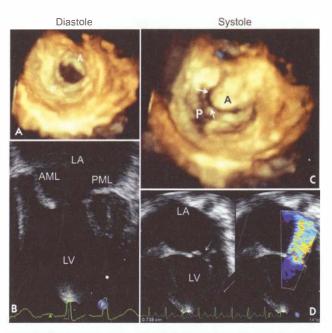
Rheumatic mitral valve disease with mitral stenosis and regurgitation. These frames are from a 10 yr old child with rheumatic heart disease with severe affliction of the mitral valve. Although the predominant lesion is mitral regurgitation, there is also some mitral stenosis. Three dimensional (3D) echocardiograms are shown in the upper panel and equivalent two dimensional frames obtained from apical four chamber views are in the lower panel; (A) The diastolic frame in the 3D image shows the mitral valve from its left atrial aspect. Note that the leaflet substance is seen in diastole; (B) Equivalent diastolic frame on 2D shows several features rheumatic affliction. The anterior mitral leaflet (AML) is thickened. The tip of the AML is oriented horizontally and does not point downwards suggesting restriction of mobility of diastolic motion. The posterior mitral leaflet (PML) is also thickened and mobility is restricted to a greater degree. The chordae tendinae beneath the PML are visibly thickened; (C) During systole the PML stays in a relatively fixed position. The free edge of the AML moves to a position above the optimal zone of coaptation between the two leaflets. The resultant regurgitation orifice is shown by white arrows in both the 3D and 2D frames. This orifice is typically crescentic and extends along the length of the AML; (D) The resultant color Doppler jet of mitral regurgitation is directed posteriorly and laterally
